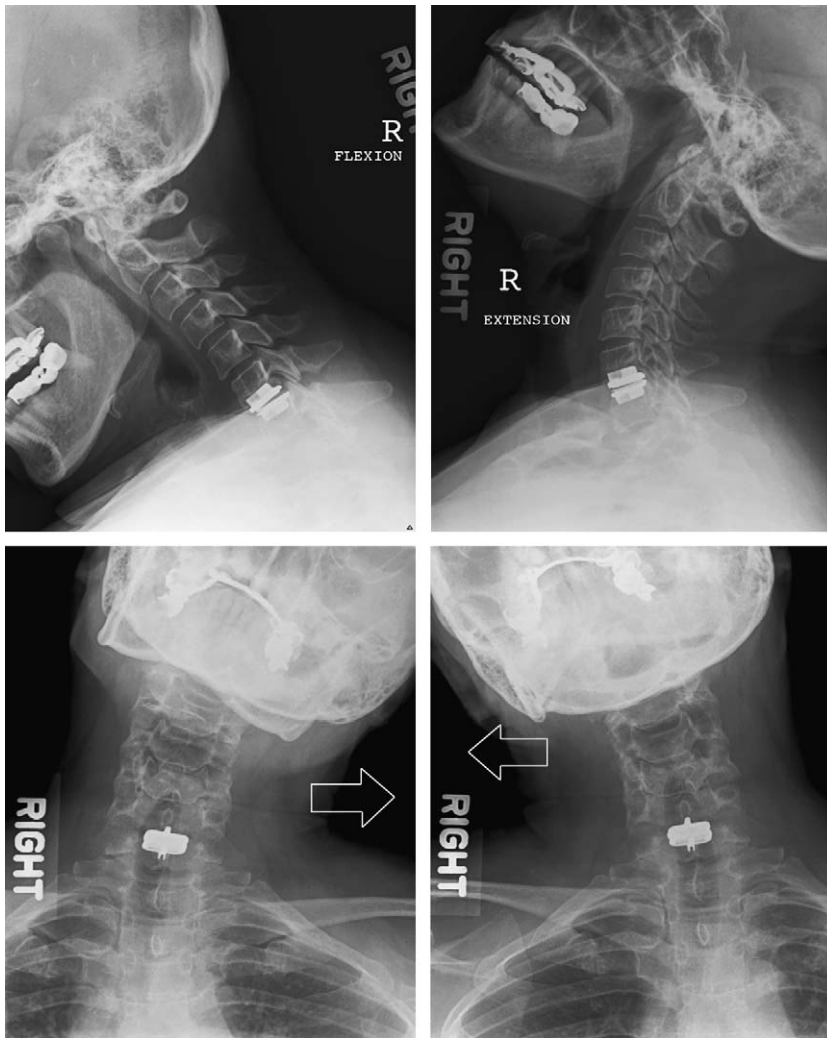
Lateral flexion (*top left*), extension (*top right*), anterior-posterior right lateral bending (*bottom left*), and anterior-posterior right lateral bending (*bottom right*) plain radiographs of the cervical spine in a 55-year-old woman with radiculopathy from central disc herniation treated with C6 to C7 discectomy and cervical disc arthroplasty with the ProDisc C artificial disc. Note that motion is preserved in all axes tested.
